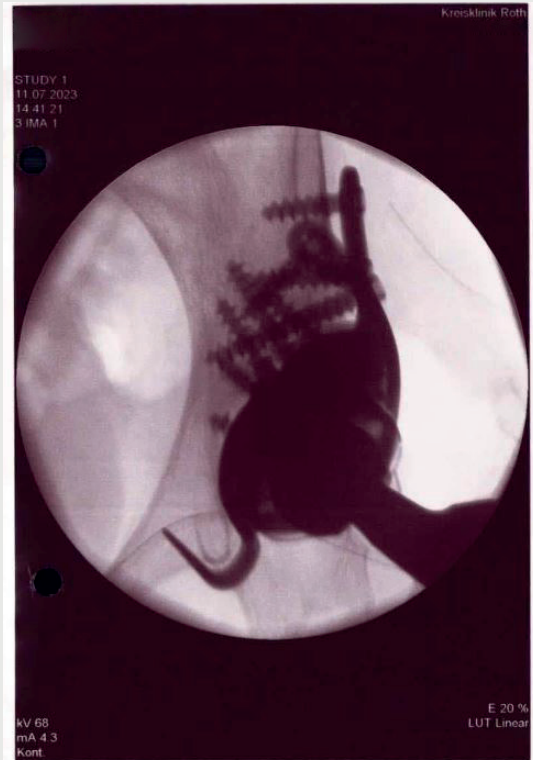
Intraoperative X-ray control of the implant position on the left
